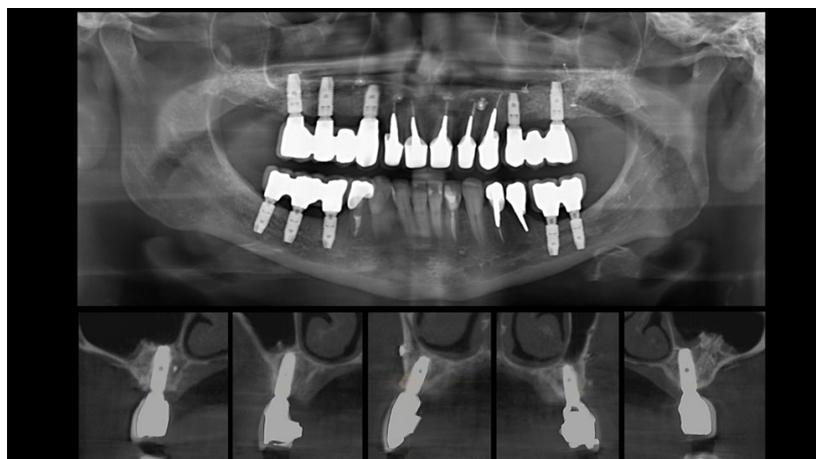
CBCT scans four years after the delivery of the final prosthesis. Implants on the lower jaw are placed simultaneously with inferior alveolar nerve lateralization.
